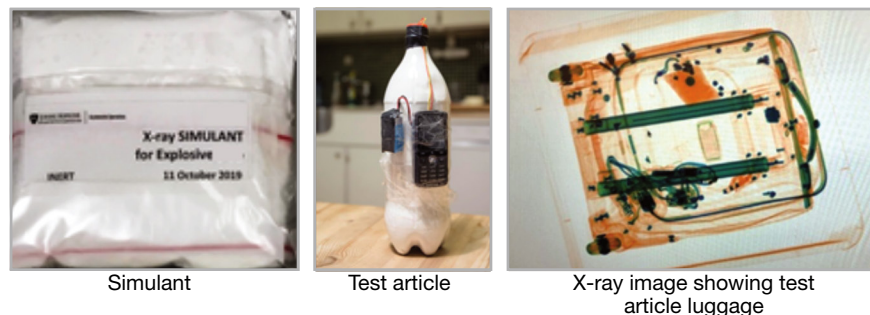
Detection-based application. Shown are a packaged simulant, a test article (an IED), and an x-ray image of a test article in luggage.
